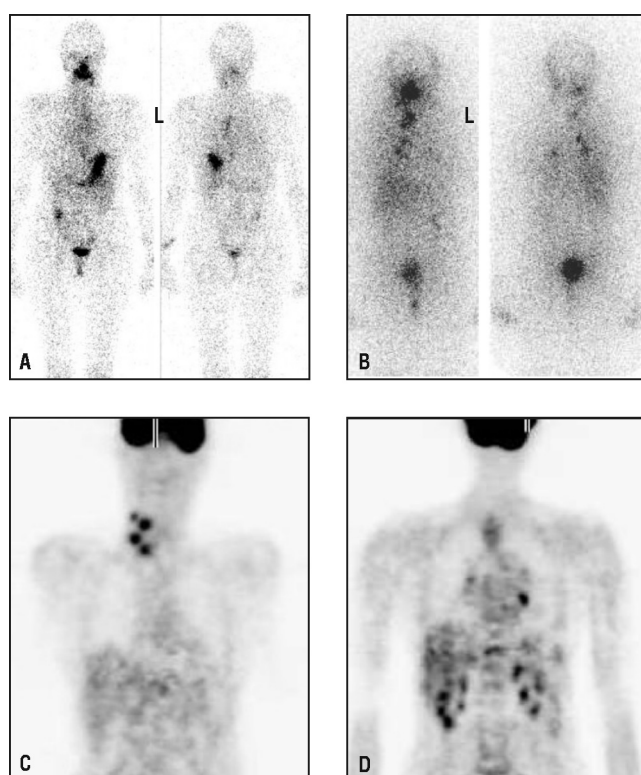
Flip-flop phenomenon A 56-year-old female with DCT and palpable recurrence in right cervical nodes associated with very high Tg. A. Anterior and posterior diagnostic ^{123}I WBS done to avoid stunning shows minimal uptake in mediastinum; B. ^{131}I post therapy WBS shows higher uptake and more pulmonary and mediastinal disease; C, D. Selected coronal sections from ^{18}F -FDG WBS showing mediastinal disease and well defined cervical lymph nodes that were clinically palpable but missed by both ^{123}I and ^{131}I WBS.
